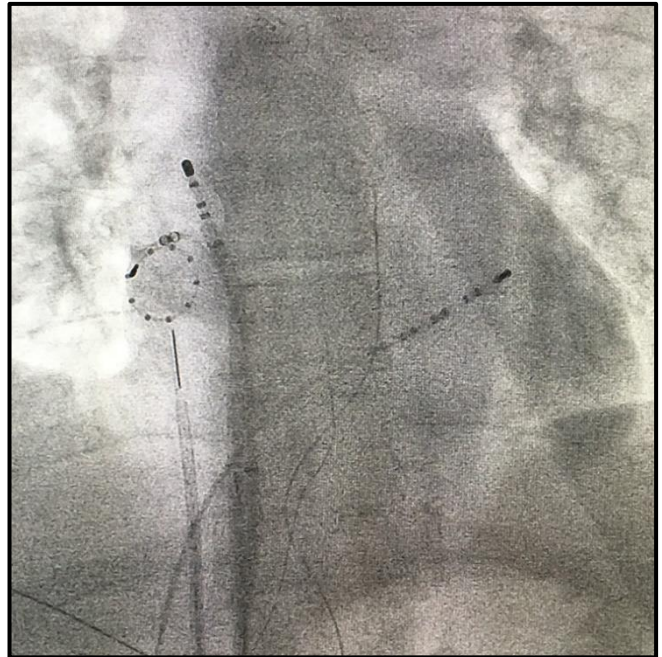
CT image taken during an ablation procedure at the Erasmus Medical Centre in Rotterdam. The patient's spinal cord (from top to bottom) and instrumentation (catheters with dotted tips) can be identified. Distinction between soft tissue, to visualise the heart, is limited.
